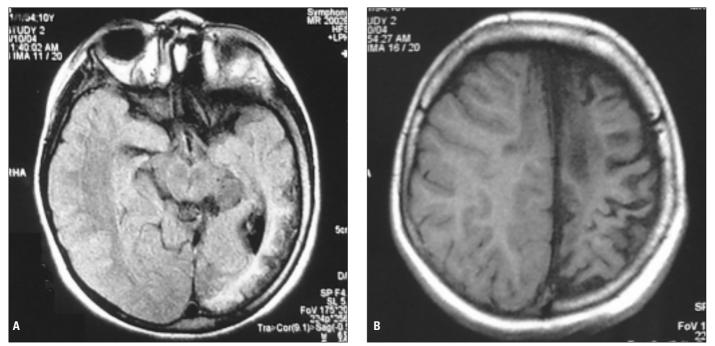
Consecutive axial proton density image at the level of basal ganglia shows bilateral multiple flow voids image (A) and T1-weighted image reveals multiple areas of infarcts of varying ages involving the left frontal, parietal, temporal, occipital, right frontal lobes (B)
